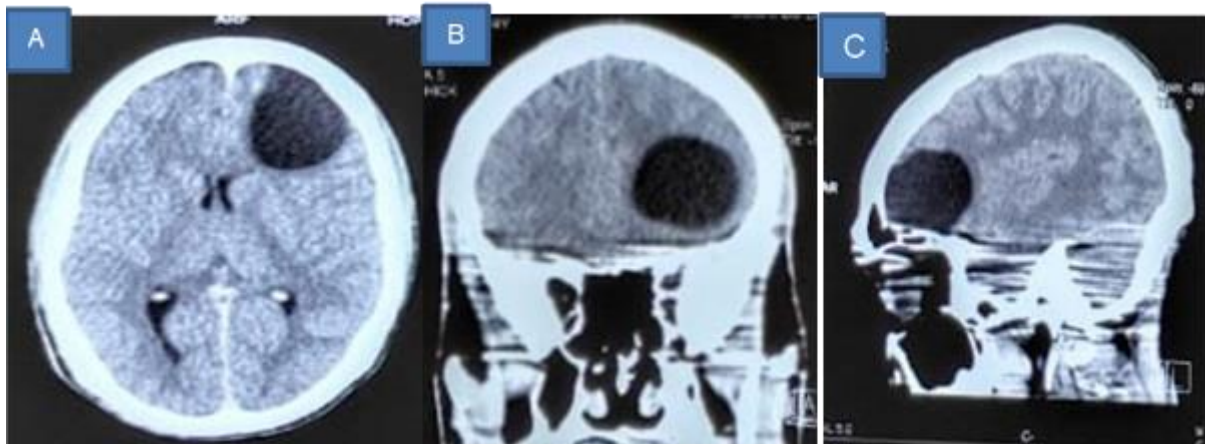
Computed Tomography Scan showed a cystic lesion with the density of CSF on (A) /Axial , (B)/Coronal and (C) Sagittal view.
